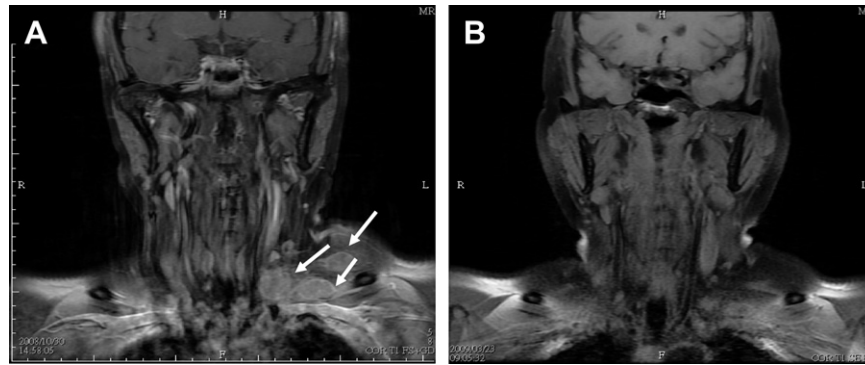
(A) Left supraclavicular lymphadenopathy demonstrated by magnetic resonance imaging (arrow). (B) The lymphadenopathy disappeared after combined chemotherapy with paclitaxel and paraplatin.
